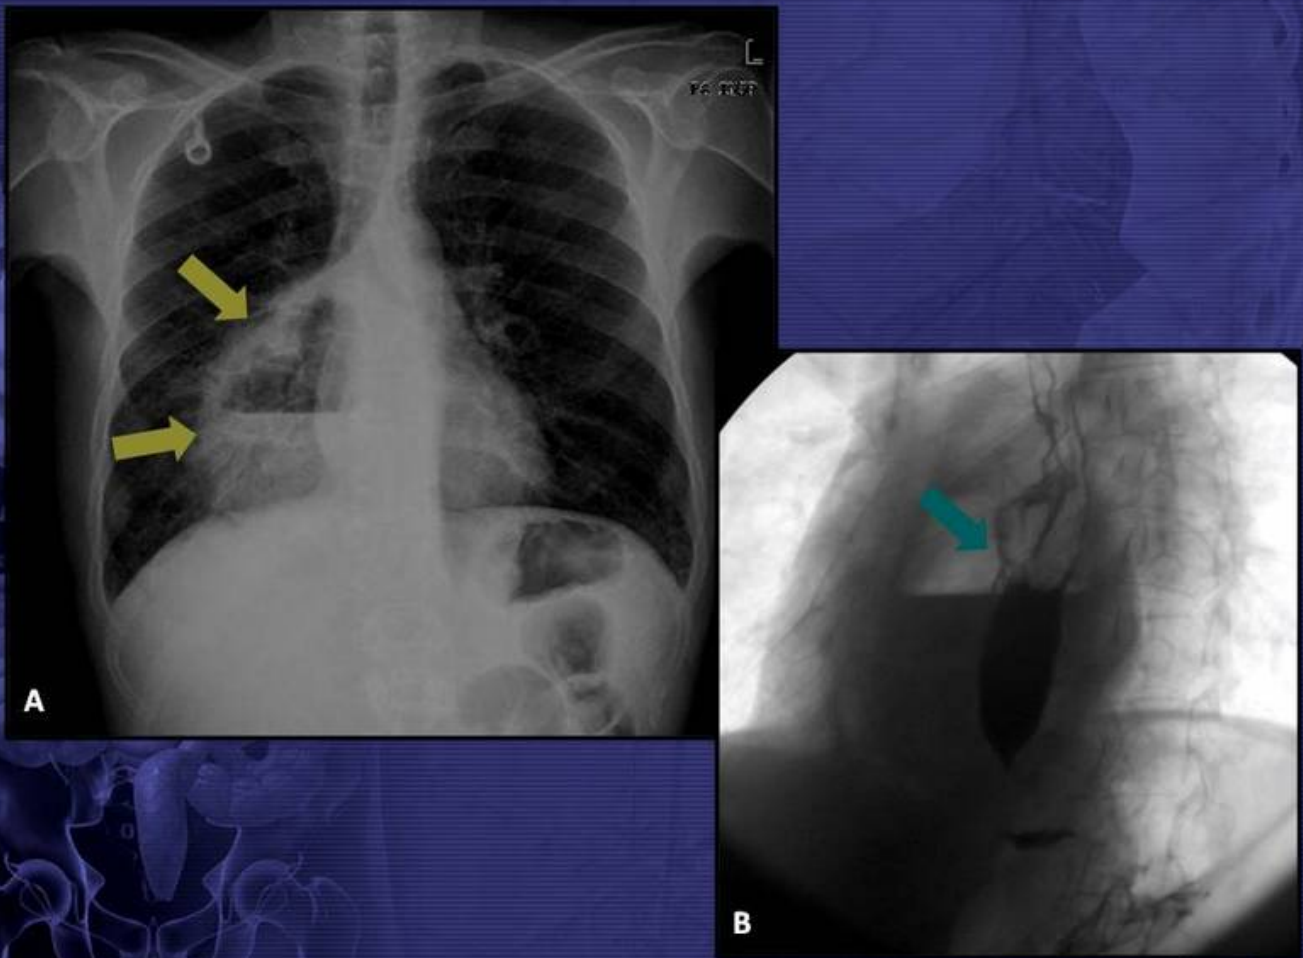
Frontal chest radiograph (A) and esophagogram (B) of a patient with known esophageal carcinoma, who developed a fistulous tract (arrow in B) between the ulcerated neoplasm and the right lung, leading to abscess formation (arrows in A).
